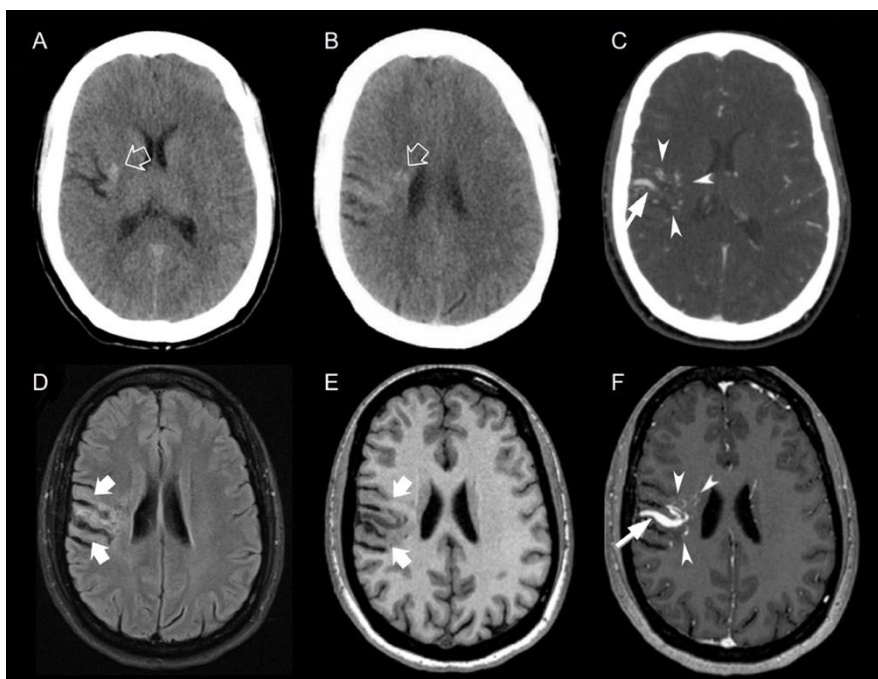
Axial unenhanced (A,B) and contrast-enhanced (C) head CT scan as well as brain MRI including axial FLAIR (D), T1WI (E) and contrast-enhanced T1WI (F) brain MRI images obtained in a young female adult presenting with seizures reveal a focal area of calcification in the right external capsule and *corona radiata* (*open white arrows*) as well as multiple small tubular structures (*white arrowheads*) in the vicinity, draining towards a venous collector that appears to have a focal area of stenosis (*thin white arrows*), compatible with a developmental venous anomaly (DVA). There is also cortico-subcortical atrophy in the draining territory of the DVA with corresponding enlargement of the adjacent sulci and body of the right lateral ventricle as well as adjacent white matter FLAIR hyperintensity (*thick white arrows*).
